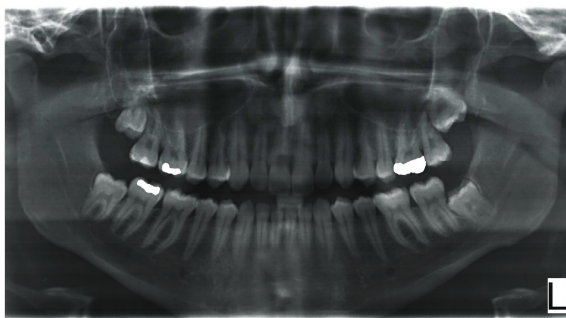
Standard orthopantomography (23 years, male)
